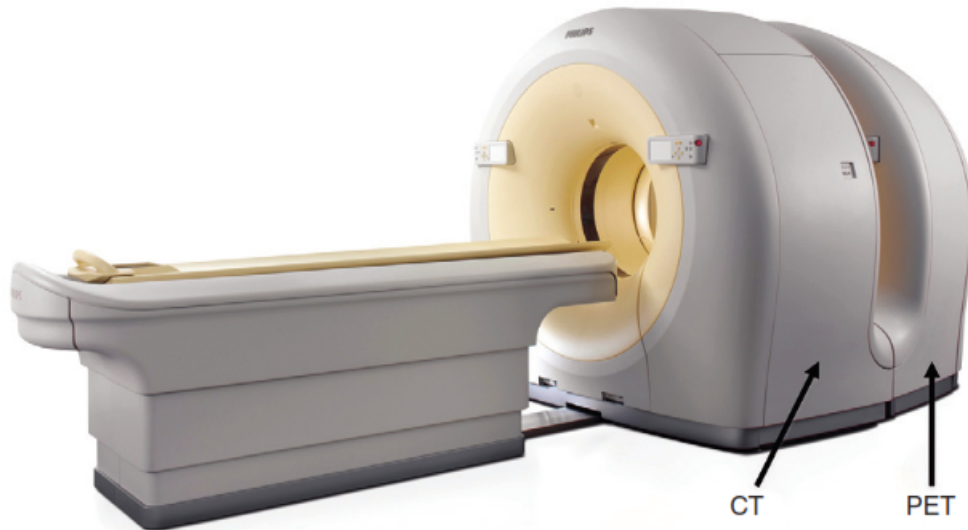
Philips Ingenuity TF PET/CT time of flight system (Cherry, Sorenson and Phelps 2012).
